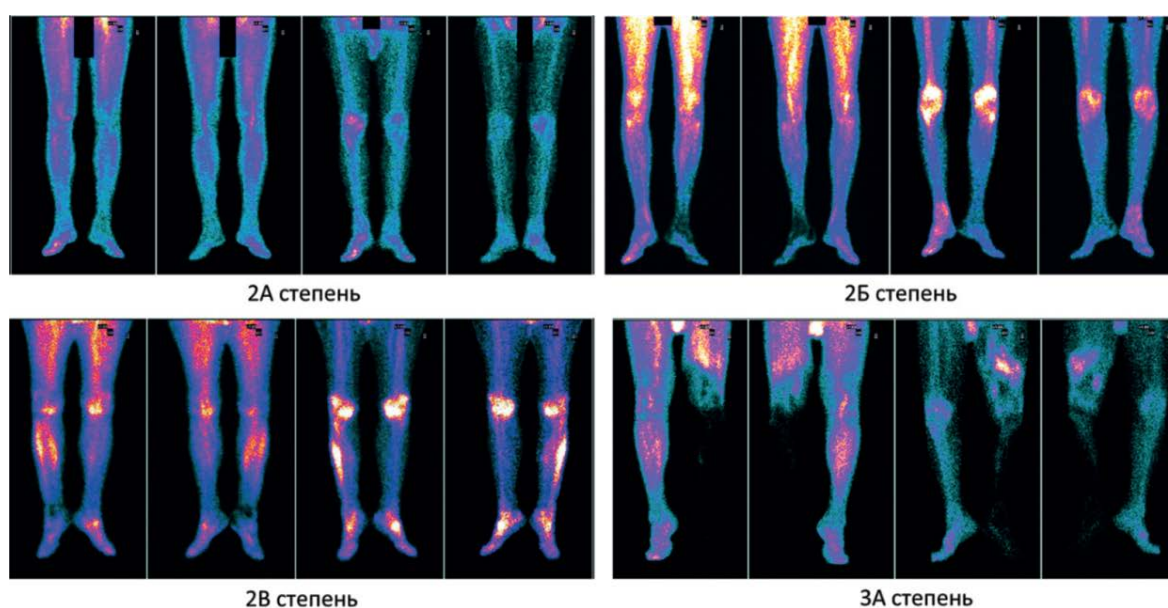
Visual signs of acute lower limb ischemia based on the scintigraphic method; for each degree of acute ischemia of the lower extremities, scintigrams are presented in the tissue phase in the anterior and posterior projections and the bone phase also in the anterior and posterior projections: grade 2A — reduced accumulation of the radiopharmaceutical in the lower third of the lower leg and foot on the left with redistribution to the bone phase; Grade 2B — decrease in microcirculation from the level of the middle third of the left lower leg and in the foot with an area of aperfusion in the ankle joint with restoration of the accumulation of the radiopharmaceutical in the bone phase; 2B — decreased microcirculation in the distal third of the right lower leg and in the foot with an area of aperfusion in the area of the ankle joint with recovery into the bone phase, as well as an area of necrotic changes in the muscles of the right lower leg with an increase in accumulation into the bone phase; 3A — aperfusion in the tissues of the left limb from the level of the middle of the left thigh with no recovery of accumulation in the bone phase, necrotic changes without the receipt of a radiopharmaceutical, as well as a demarcation area in the form of emerging necrosis with hyperfixation of the radiopharmaceutical in the middle third of the left thigh
